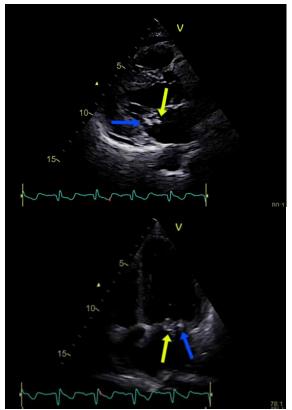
Left: Transthoracic echocardiogram parasternal long axis view showed vegetation at anterior mitral leaflet (yellow arrow) and posterior mitral leaflet (blue arrow). Right: Transthoracic echocardiogram apical four chamber view showed vegetation at anterior mitral leaflet (yellow arrow) and posterior mitral leaflet (blue arrow)
